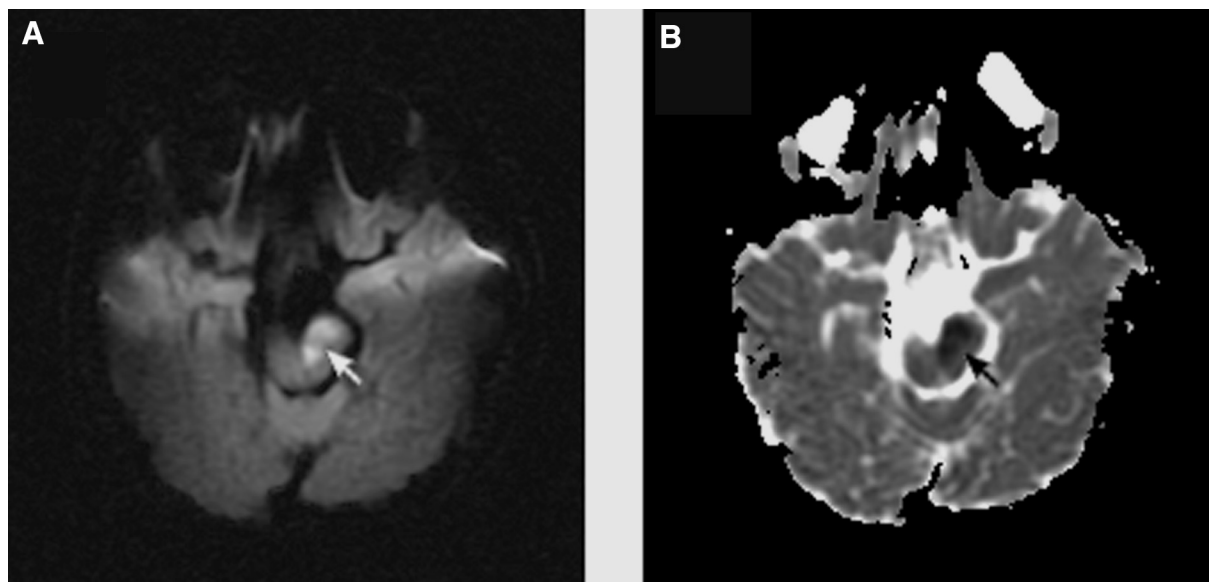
Diffusion-weighted axial magnetic resonance image (DWI, repetition time = 8000 ms, echo time = 71.7 ms, $b = 1000$) (A) and apparent diffusion coefficient (ADC) map (B) showed acute infarct in the left cerebral peduncle (arrows) with characteristic hyperintensity on DWI and hypointensity on the ADC map.
